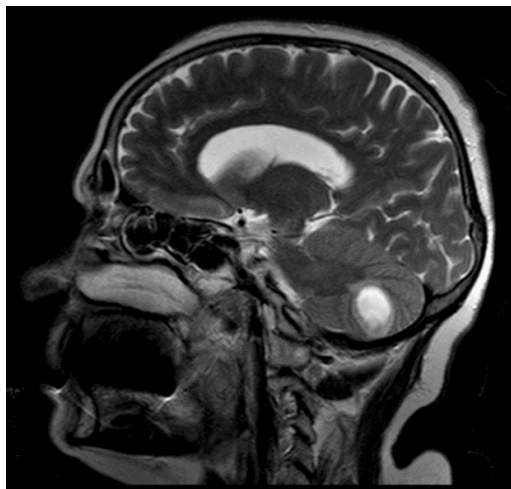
Preoperative MRI scan showing CIM with 13mm caudal dislocation of the cerebellar tonsils through the foramen magnum.
